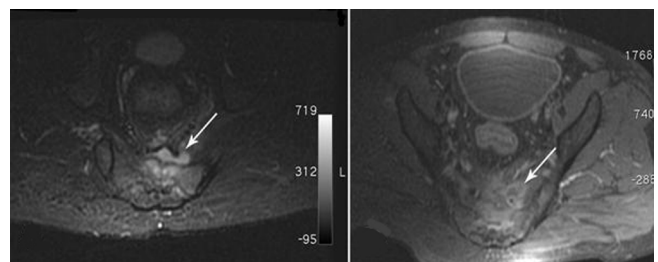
Axial T2-weighted fat-suppression image and T1 weighted fat-suppression image following intravenous Gd administration show a contrast-enhancing signal increase consistent with sacral osteomyelitis and associated presacral abscess. In addition, a presacral cystic mass pressing on the left lumbosacral plexus is seen (arrow).
